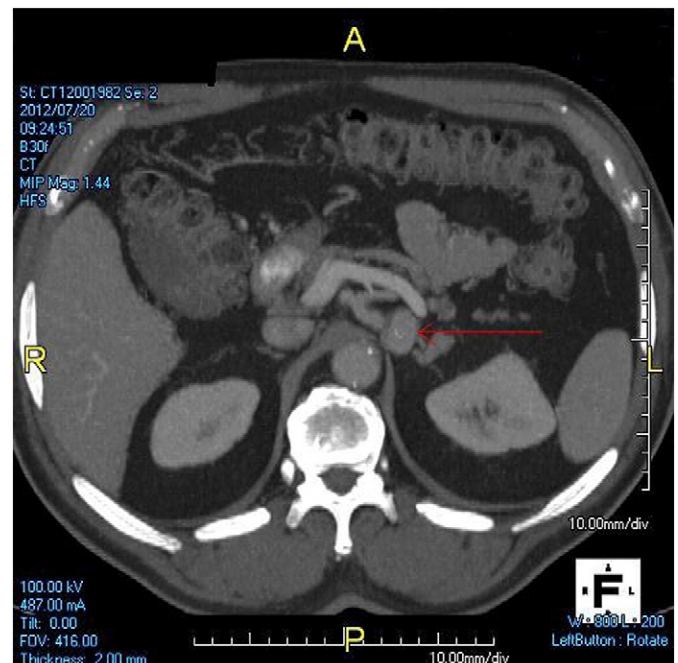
CT angiogram of the splenic arterial aneurysm.
